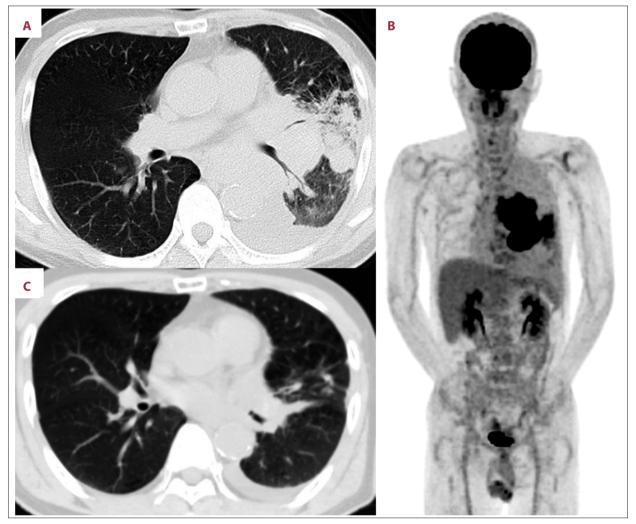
CTs and PET/CT images before and after chemoradiotherapy. (A) CT scan at the first visit shows a primary lesion at left hilar area, enlarged mediastinal lymph nodes, and pleural effusion. (B) PET/CT scan does not show any distant metastasis before chemoradiotherapy. (C) CT scan after chemoradiotherapy shows primary lesion and lymph nodes shrinking.
